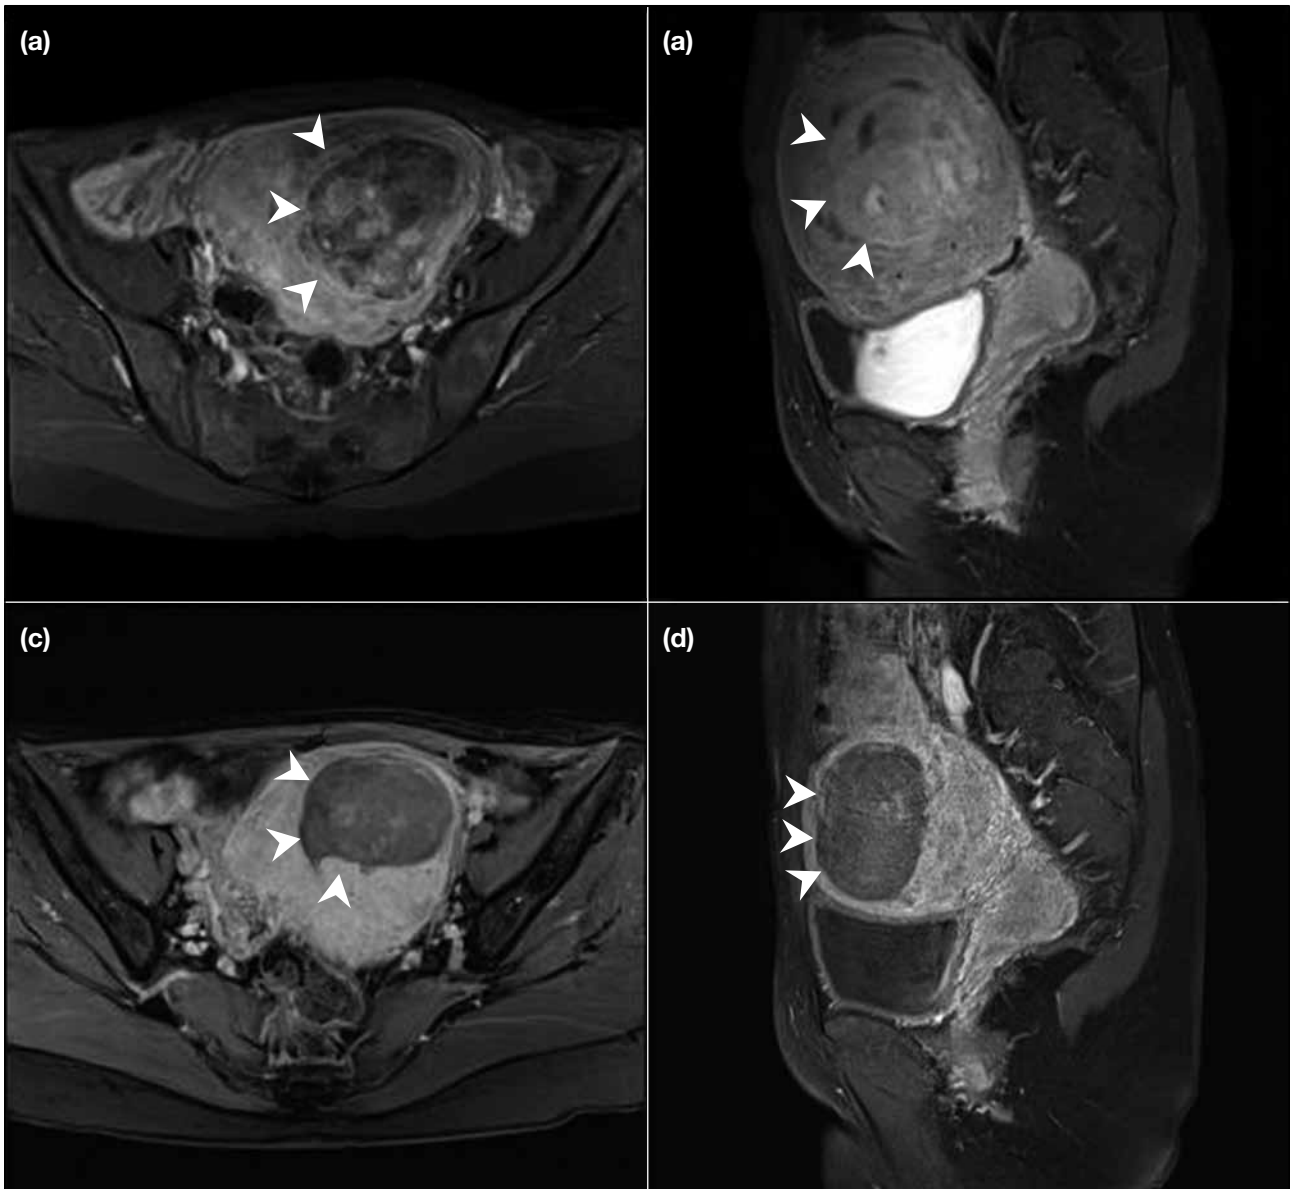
(a) Axial and (b) coronal T1-weighted contrast-enhanced magnetic resonance (MR) images showing a large fibroid on the left side of the uterus with internal enhancement. The uterus is also distended. Mass effect is also seen on the adjacent urinary bladder (arrowheads). (c) Axial and (d) coronal T1-weighted contrast-enhanced MR images 6 months after uterine artery embolisation showing decrease in size of the fibroid with decreased enhancement suggesting devascularisation (arrowheads). Uterine distension and mass effect on urinary bladder have also decreased.
